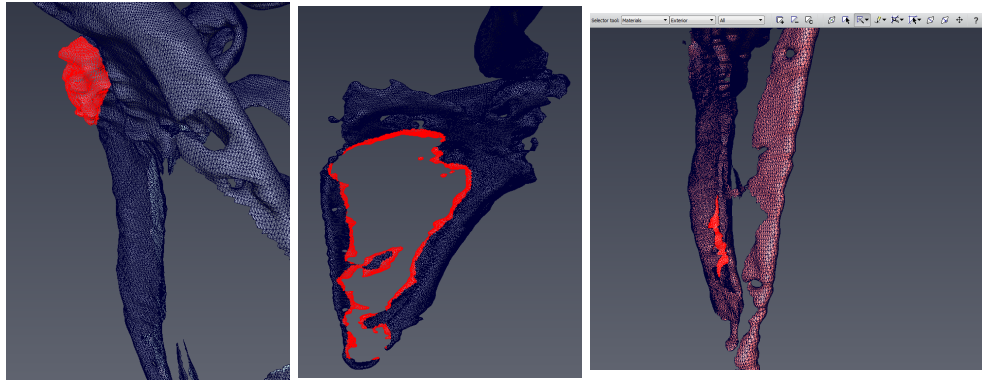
Surfaces to be removed from the CT postop for the surfaces alignment. *On the right, a typical artefact's due to the presence of the metallic part. On the center and right the surfaces are closed automatically by Amira because of lack of information on the central part. Still, this closing is not correct.*
